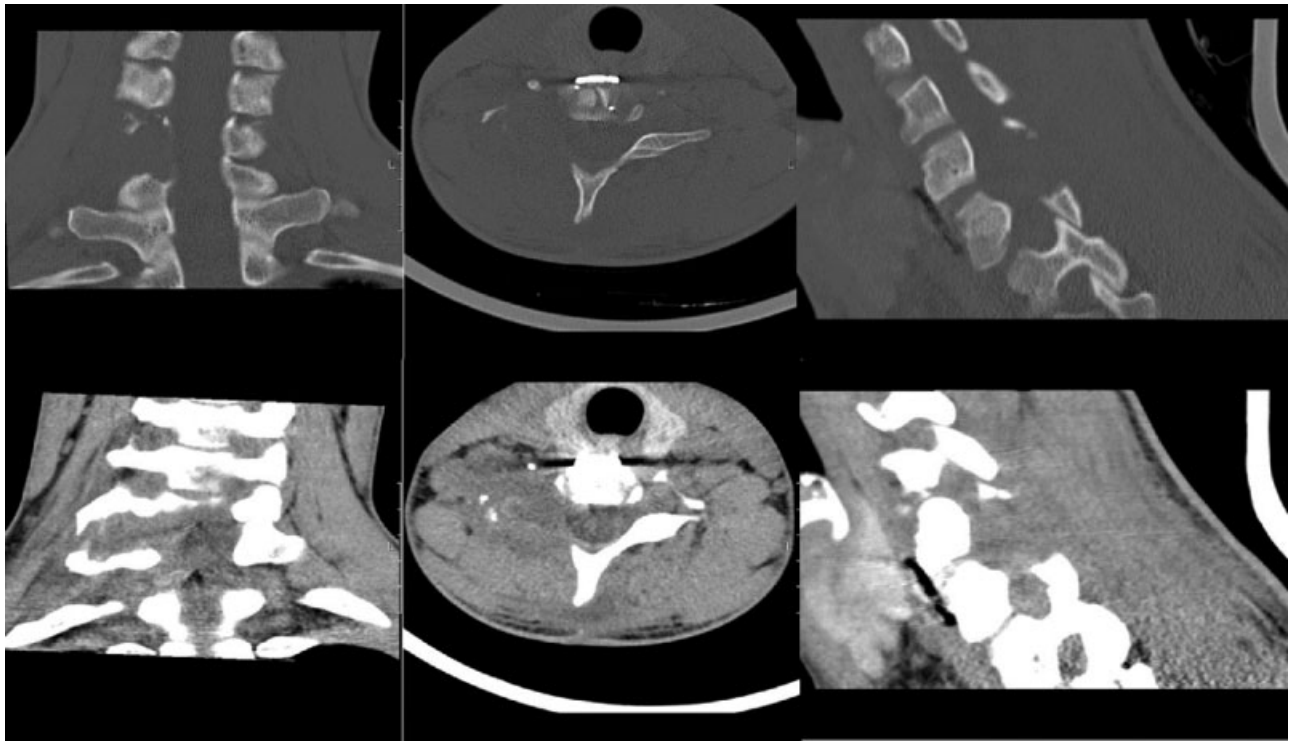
Post-operative cervical CT scan: complete surgical resection.
